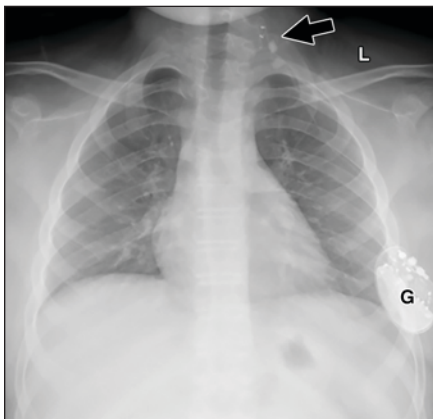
15-year-old girl with seizures and appropriately positioned vagal nerve stimulator. Frontal chest radiograph shows generator (G) in left chest wall with leads (*arrow*) extending to left neck.
